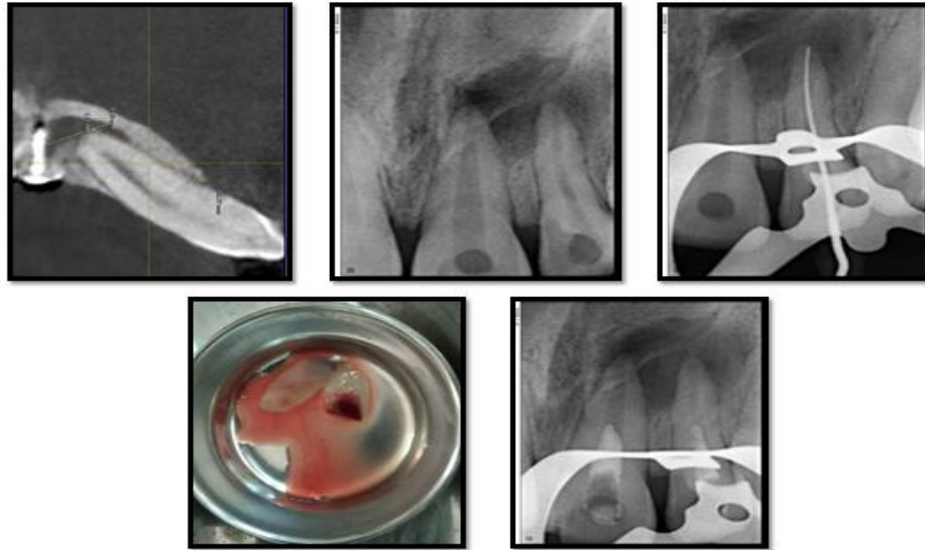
(a,b,c,d,e): Showing pre-op CBCT, pre-op radiograph, working length, PRF, Insertion of PRF respectively.
